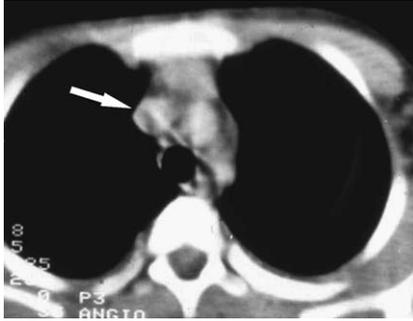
Chest CT scan showing superior vena cava thrombosis (*arrow*) in a 13-year-old boy with primary APS.
